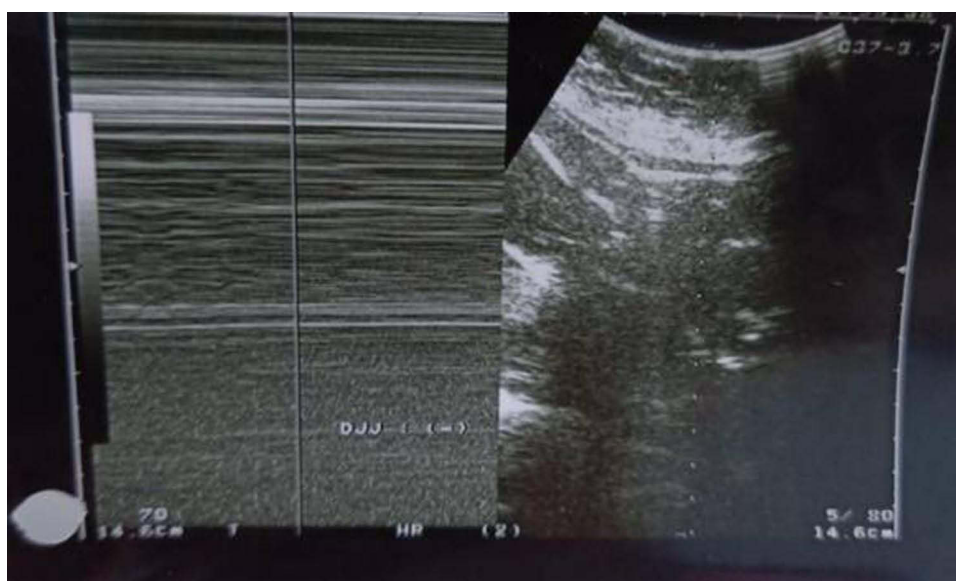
Ultrasound examination found that the fetal heartbeat was absent.
